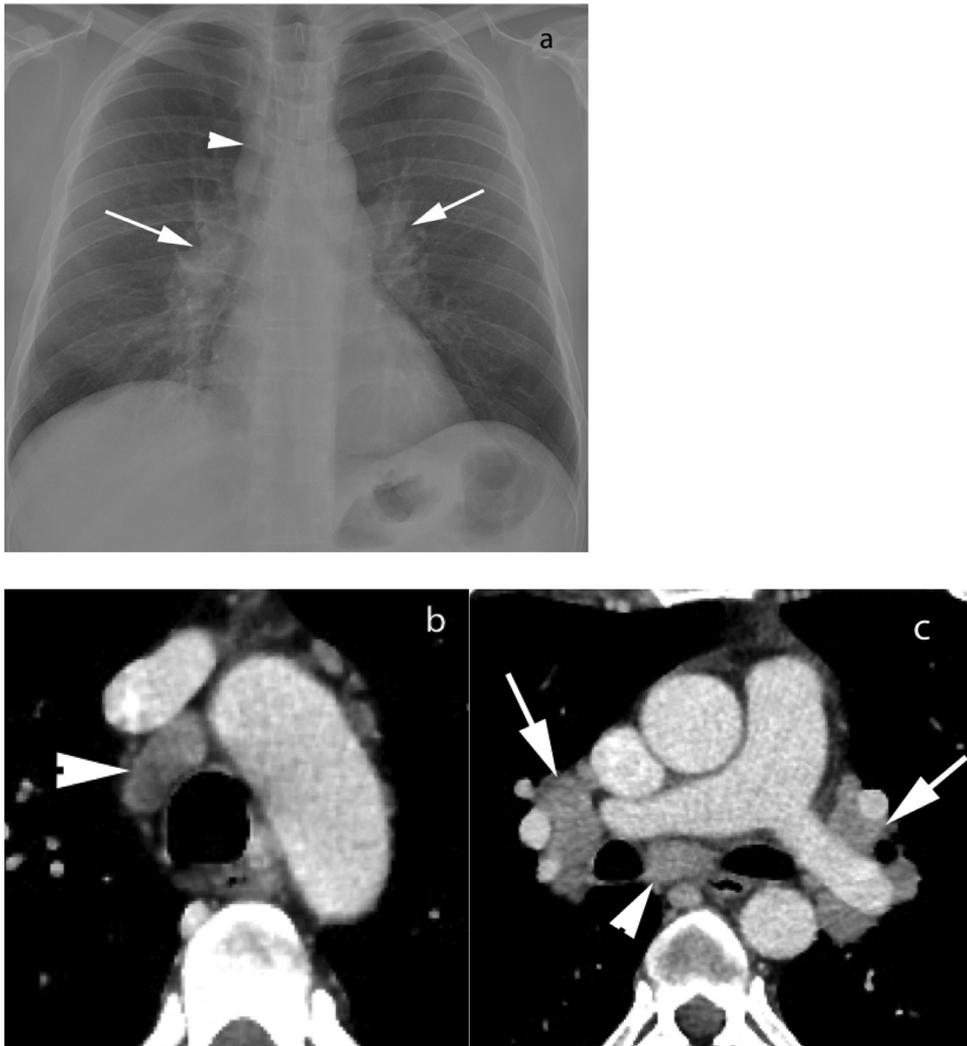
(a-c) Frontal chest radiograph (a) and CT showing mediastinal (arrowheads) and bilateral hilar (arrows) lymphadenopathy. CT, computed tomography.
